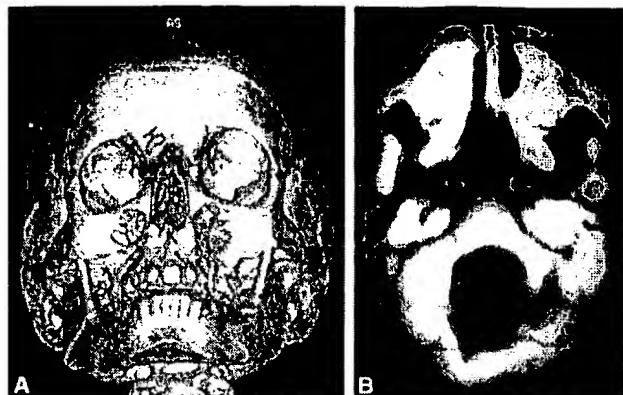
Skull radiographs of two individuals with SMMCI. A: Three-dimensional computer-generated scan of individual 22 (same as J and K in Fig. 2). B: CT scan of individual with SMMCI and nasal stenosis on the left side. Numbers of individuals are the same as in Hall et al., 1997.
